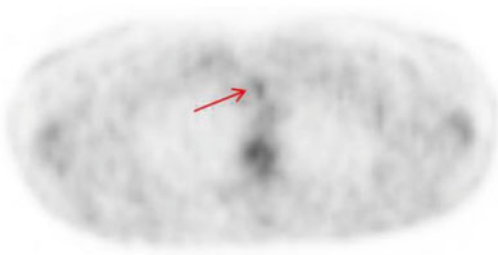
Interim PET/CT: mild hypermetabolism at the anterior mediastinum (D-5PS score 3)
